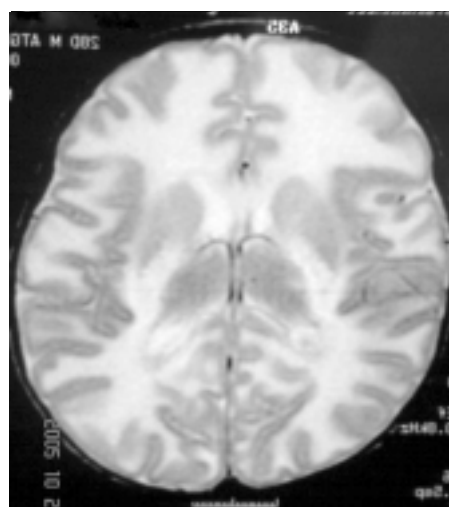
MRI showing diffuse demyelination in an infant with Krabbe disease. The hypotonia was the result of associated peripheral neuropathy.
